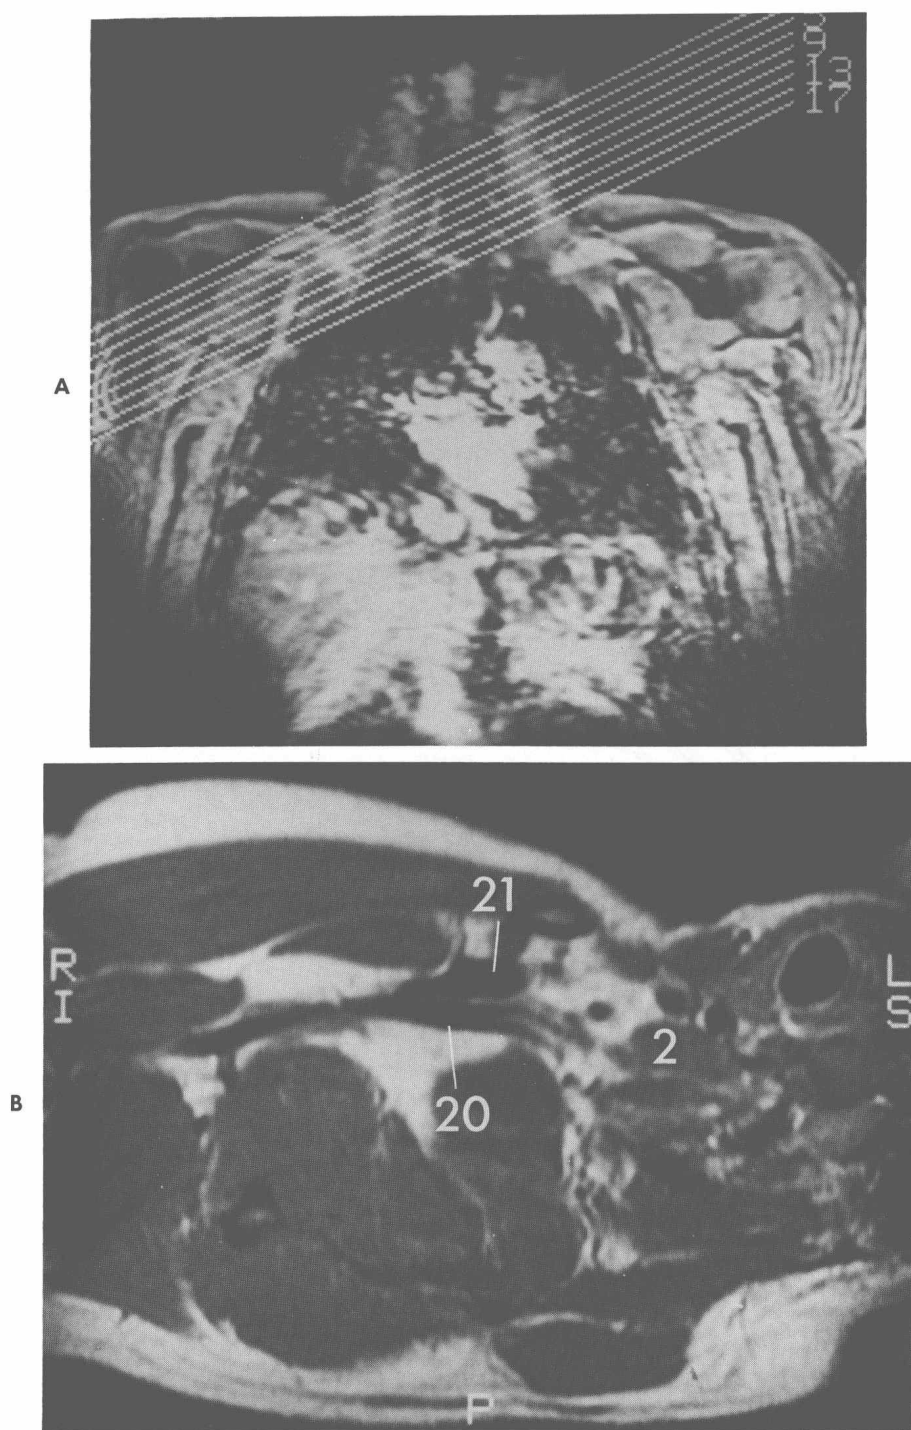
Axial oblique MR imaging of the supraclavicular fossa and axilla. A, Scout film for oblique film scans parallel course of neurovascular bundle. B, Scan at roof of the axilla demonstrates axillary vein (21) and artery (20) distal to their separation by anterior scalene muscle (2).
